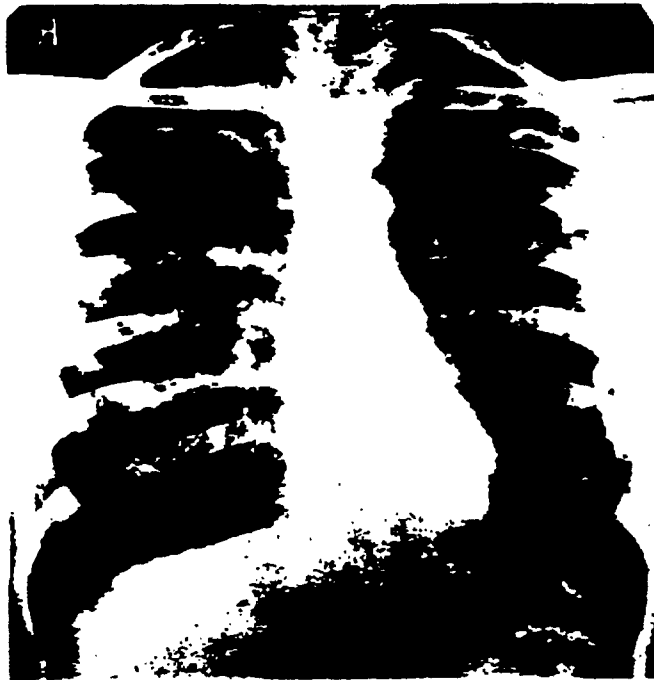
Normal chest radiograph. Male aged 40 years.
